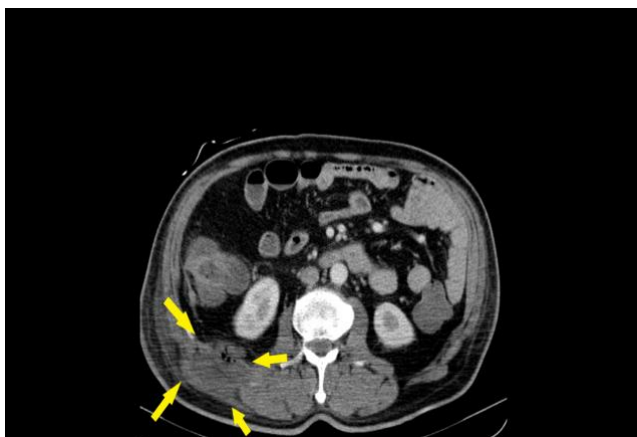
CT scan shows a right flank abscess of 70 * 50 mm in size.
